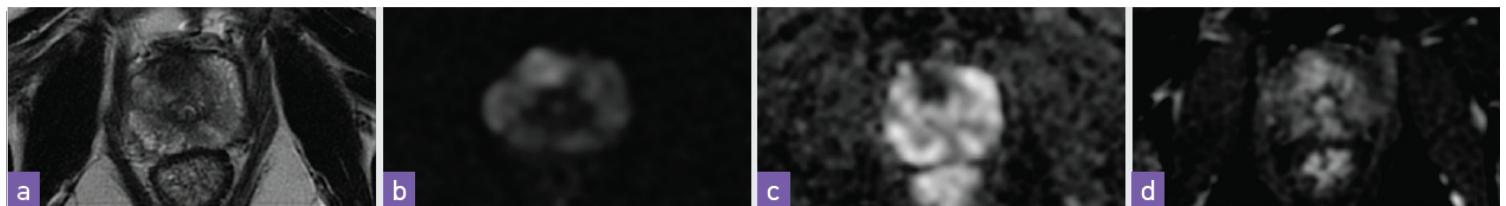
Prostate Carcinoma in the anterior gland shows a lesion suspicious for prostate carcinoma, with similar findings to the lesion in Figure 1: a) T2; b) DWI; c) ADC; d) Dynamic post contrast
